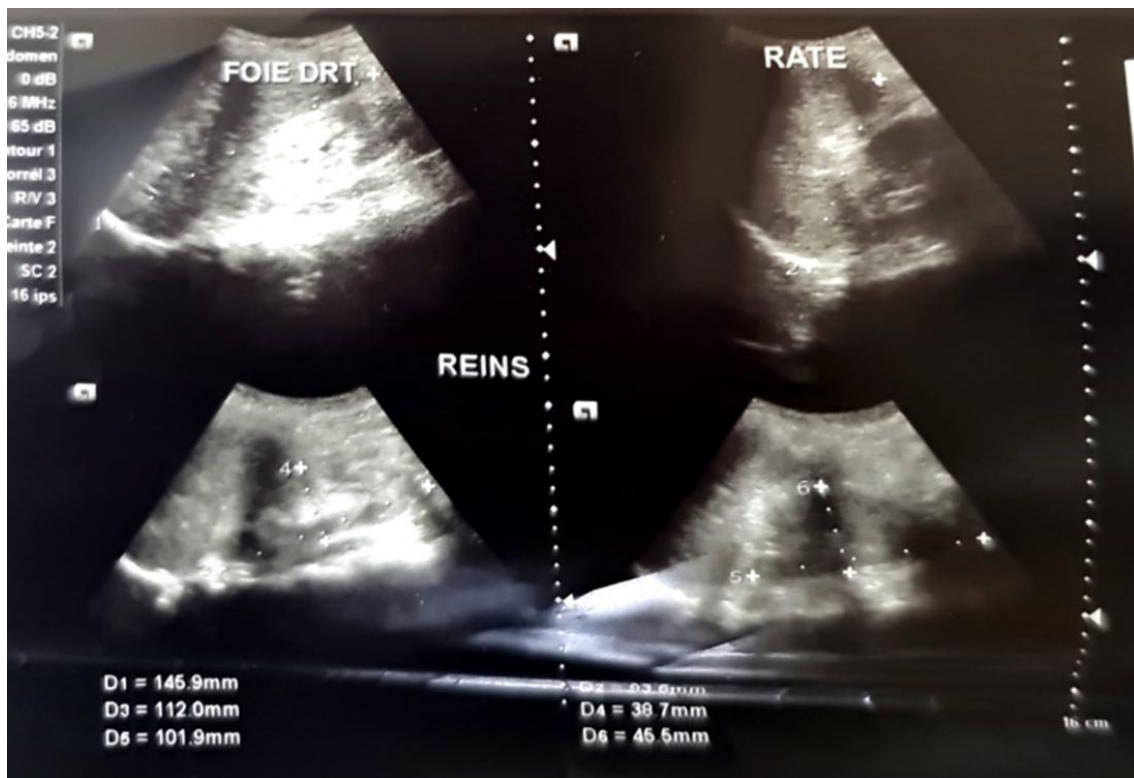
Ultrasound image of both kidneys showing echogenic kidneys with loss of its cortico-sinus differentiation suggestive of bilateral renal suffering.
